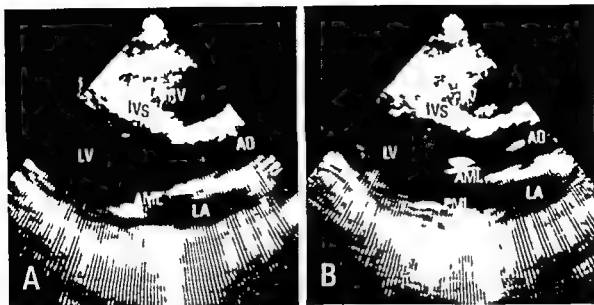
Cross sectional echocardiograms along the long cardiac axis in a normal subject. Panel A is recorded in systole and panel B shows the early diastolic image of the heart. The posterosuperior region of the PML is solid wall tissue and revealed no abnormal findings. Abbreviations: RV = right ventricle, AO = aorta, IVS = inter ventricular septum, AML = anterior mitral leaflet, PML = posterior mitral leaflet, LA = left atrium, LV = left ventricle.
